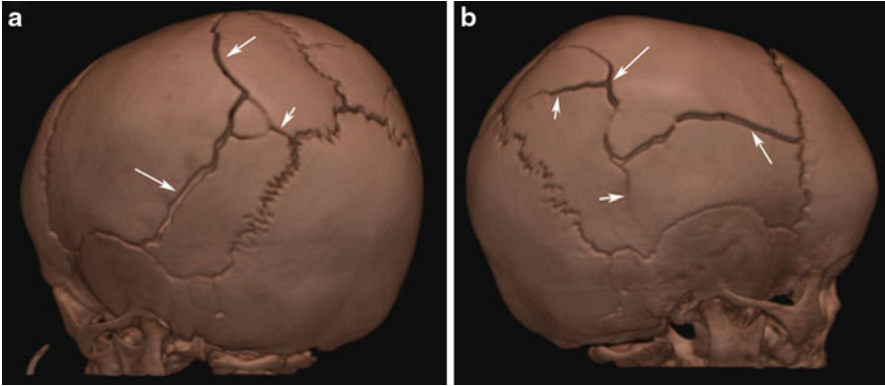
3D reconstructed CT images showing complex bilateral parietal bone fractures (*arrows*) in this infant (right parietal bone in figure (a) and left parietal bone in figure (b)) who also had subdural hematoma
